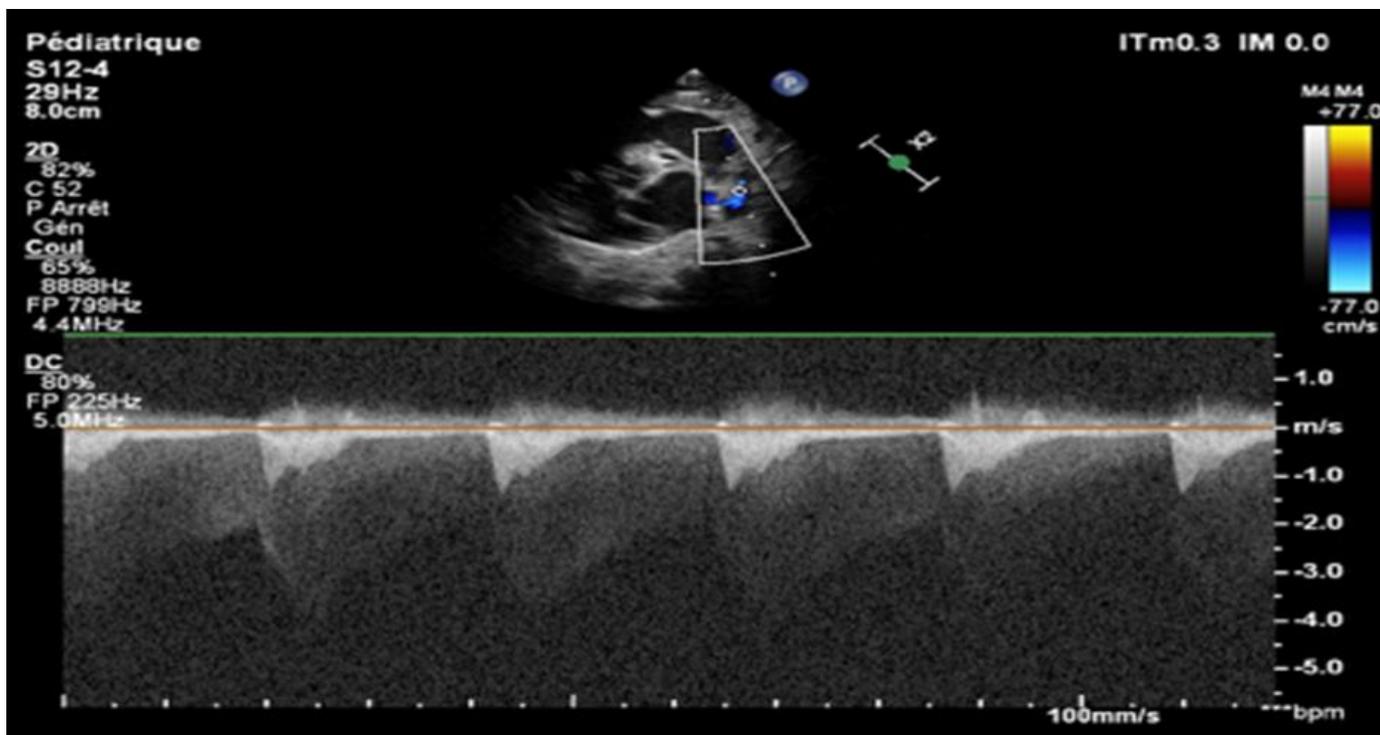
Ultrasound image of blood flow in aortic coarctation using continuous Doppler.
